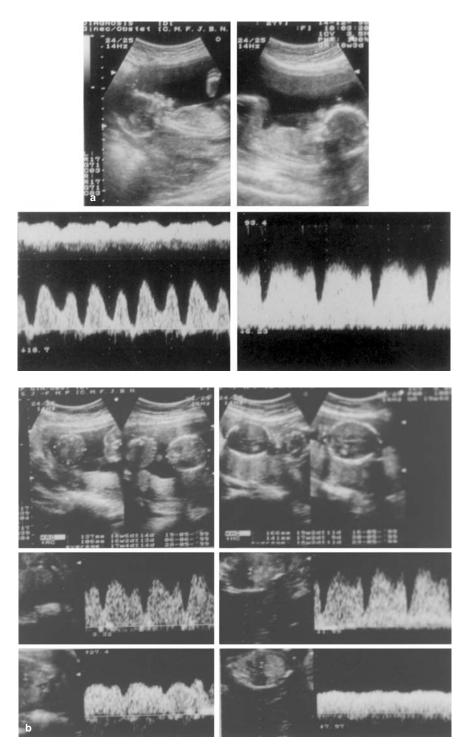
(a) Doppler blood flow waveforms in the ductus venosus (DV) obtained in case 1 at 18 weeks of gestation, when twin-to-twin transfusion was detected. Abnormal flow in the DV (absent flow during atrial contraction) and umbilical vein (pulsatile flow) was recorded in the recipient. (b) Improvement DV waveforms in the recipient (case 1) 1 week after fetoscopic laser coagulation
